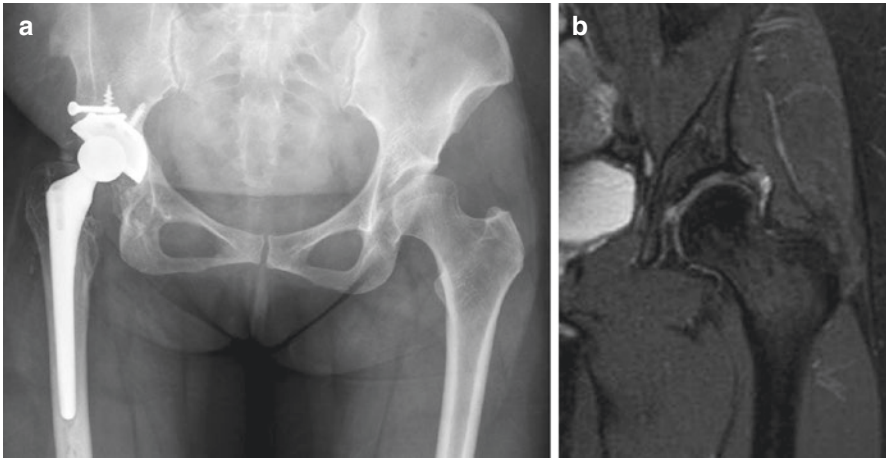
(a) A 43-year-old female patient with right total hip arthroplasty for Crowe IV high dislocation that was done 12 years previously. She suffered severe left hip pain. The anterior-posterior view showed Crowe I dysplasia without narrowing of the joint space (Tonnis grade 0 [16]). (b) The T2 magnetic resonance image revealed a tear of the labrum with a cyst formation (these pictures were agreed by the patient for publication)
